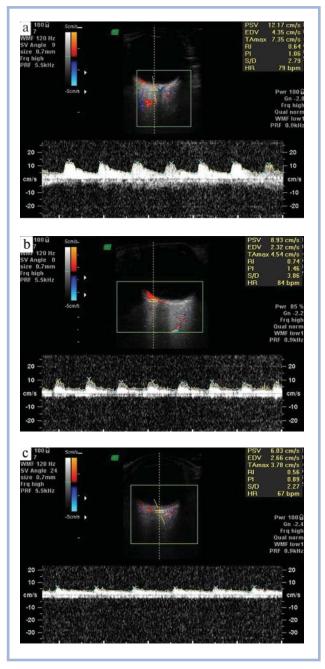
Doppler spectrum of blood flow in the sPCA.
